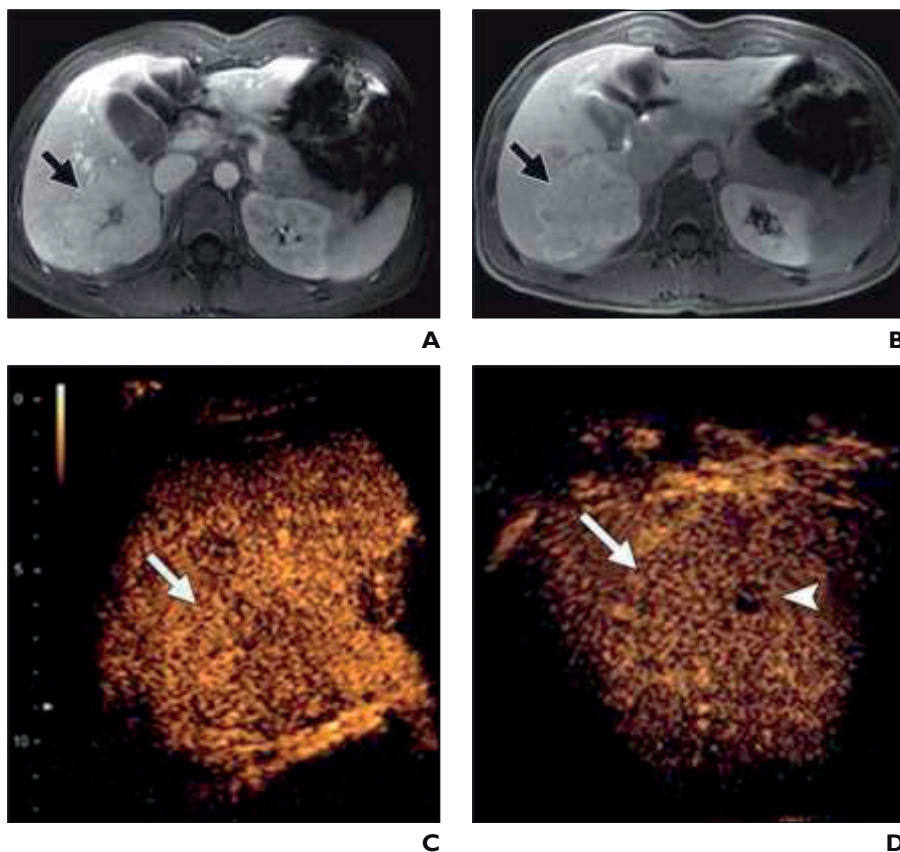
25-year-old woman with focal liver lesion who underwent contrast-enhanced sonography and MRI with liver-specific contrast agent; findings were concordant for focal nodular hyperplasia. A and B, Images from MRI with liver-specific contrast agent show lesion (arrow, A and B) on right lobe of liver (in liver segments V–VIII) with features typical of focal nodular hyperplasia, including progressive enhancement of central scar (A) and hyperintensity on delayed hepatobiliary excretory phase (B). C and D, Contrast-enhanced sonography images show lesion (arrow, C and D) is isodense and heterogeneous compared with surrounding parenchyma. Image obtained after IV contrast administration shows centrifugal filling and retainment of contrast in lesion (C), with central scar evident on late phase image (arrowhead, D).
